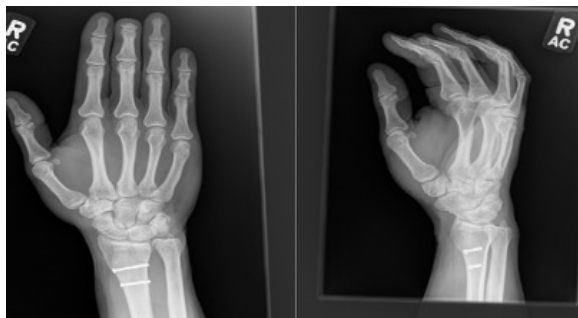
AP and lateral radiographs at 1-year time shows healing of fracture
